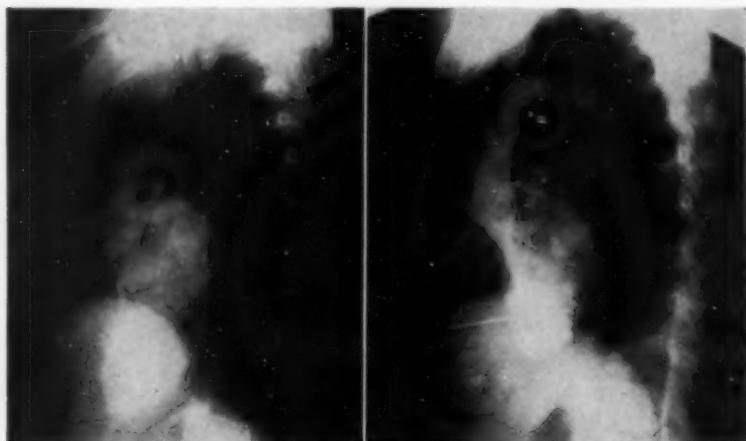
Preoperative and postoperative left ventriculography. The left x-ray shows massive regurgitation from the left ventricle into the left atrium. The x-ray on the right shows minimal mitral valve leak following a Nichols operation for the four plus insufficiency which was present.
